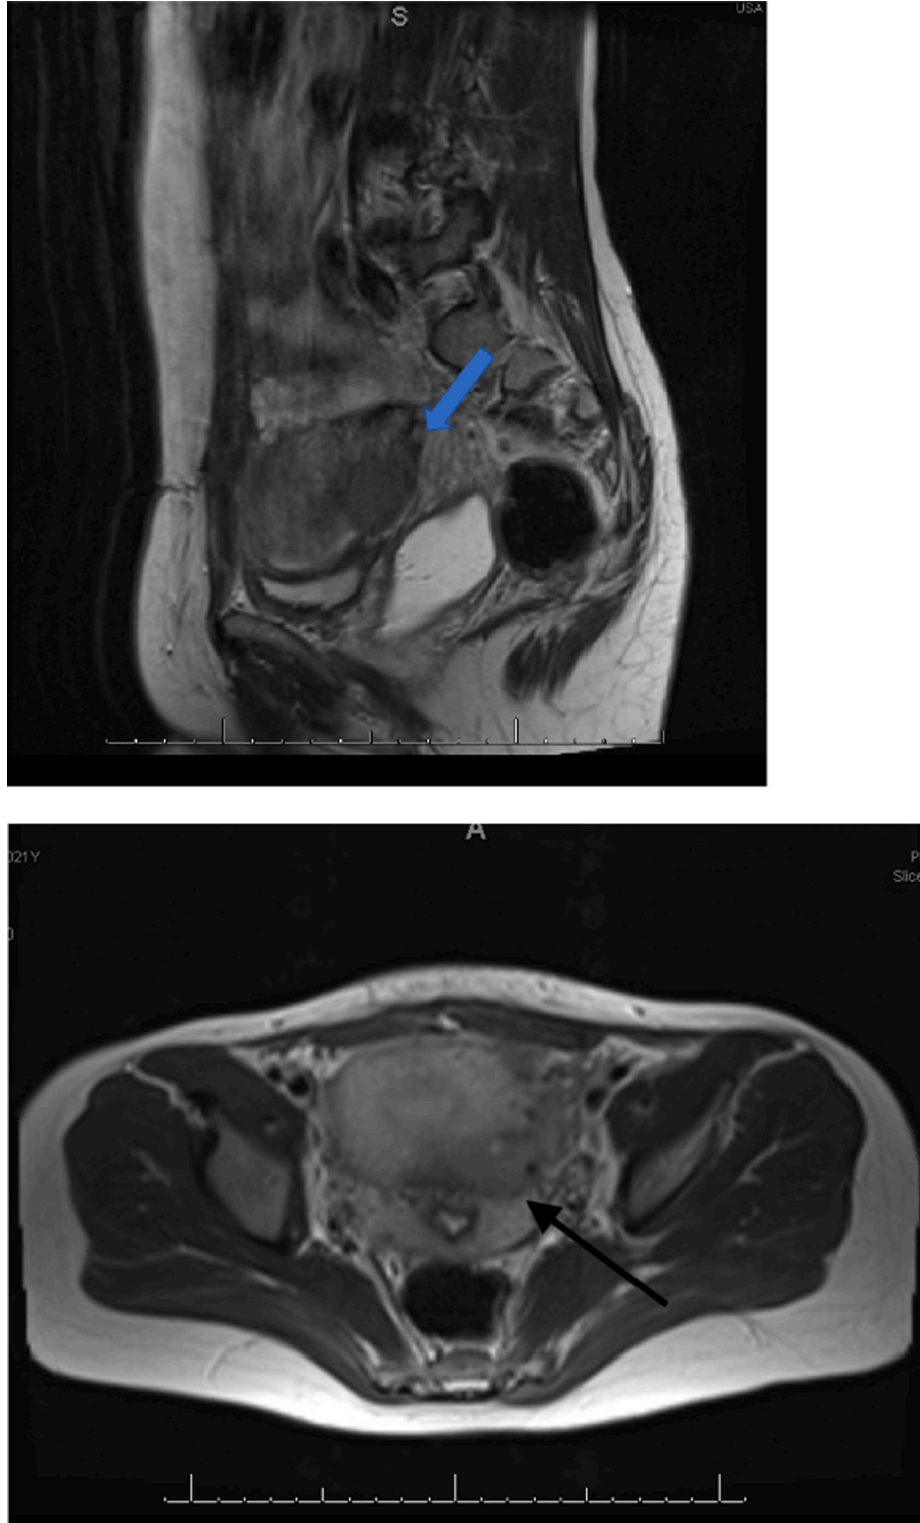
Sagittal (A) and axial (B) T2 MRI images showing a lesion most consistent with a hematoma, a 4.1 cm × 1.6 × 2.2 cm hypointense lesion that did not enhance with contrast).
